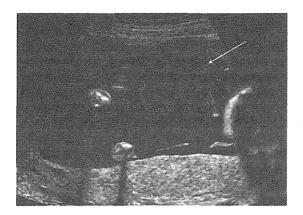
Ultrasound demonstrating chorioamniotic membrane separation noted after laser surgery for twin-twin transfusion syndrome. The white arrow indicates the separated layer
